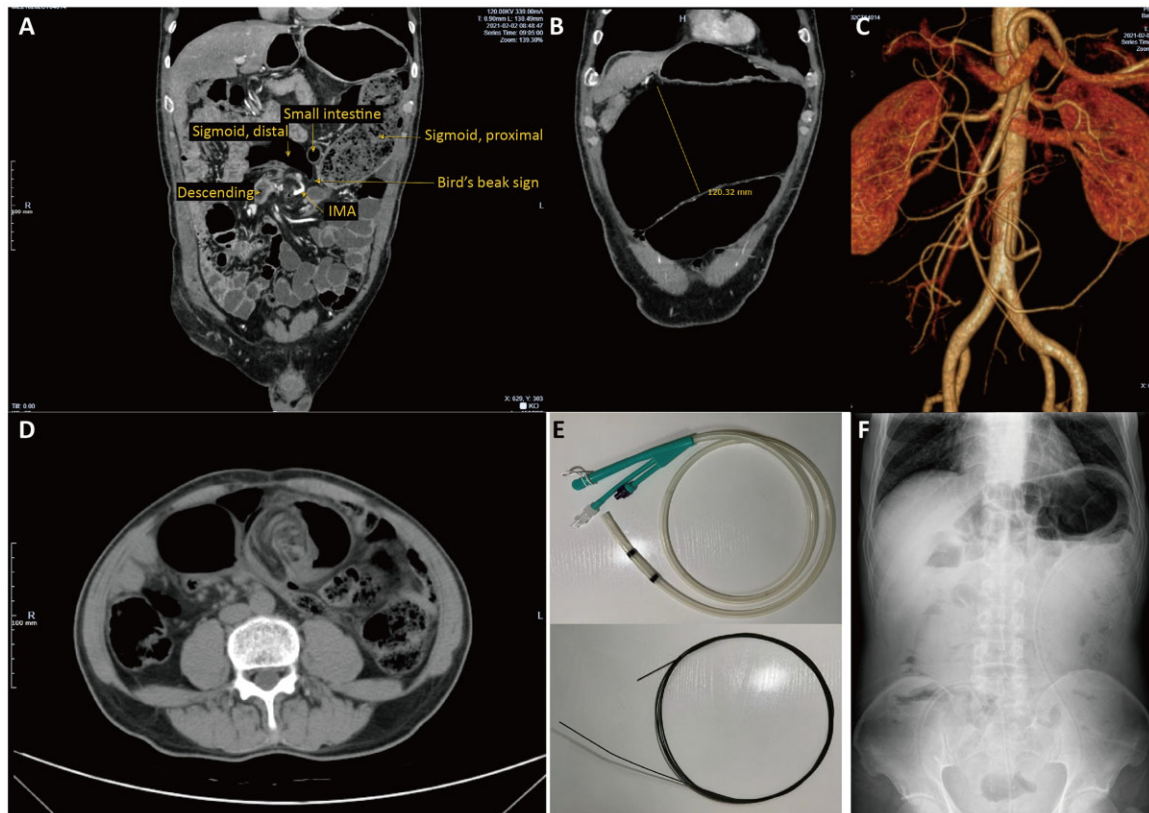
Images of the patients and the TaIT. (A) The coronary plane showing a bird's beak sign. (B) The coronary plane shows the sigmoid colon with maximal diameter. (C) The vascular reconstruction imaging showing the sigmoid and left colonic arteries dragged to the right. (D) The axial plane showing a whirl sign (taken on 15 November 2021). (E) The Cliny TaIT (up) and the matched guide wire (down). (F) The abdominal plain film taken just before the TaIT was withdrawn showing the tube in position and the shrunken colon. IMA, inferior mesenteric artery.
